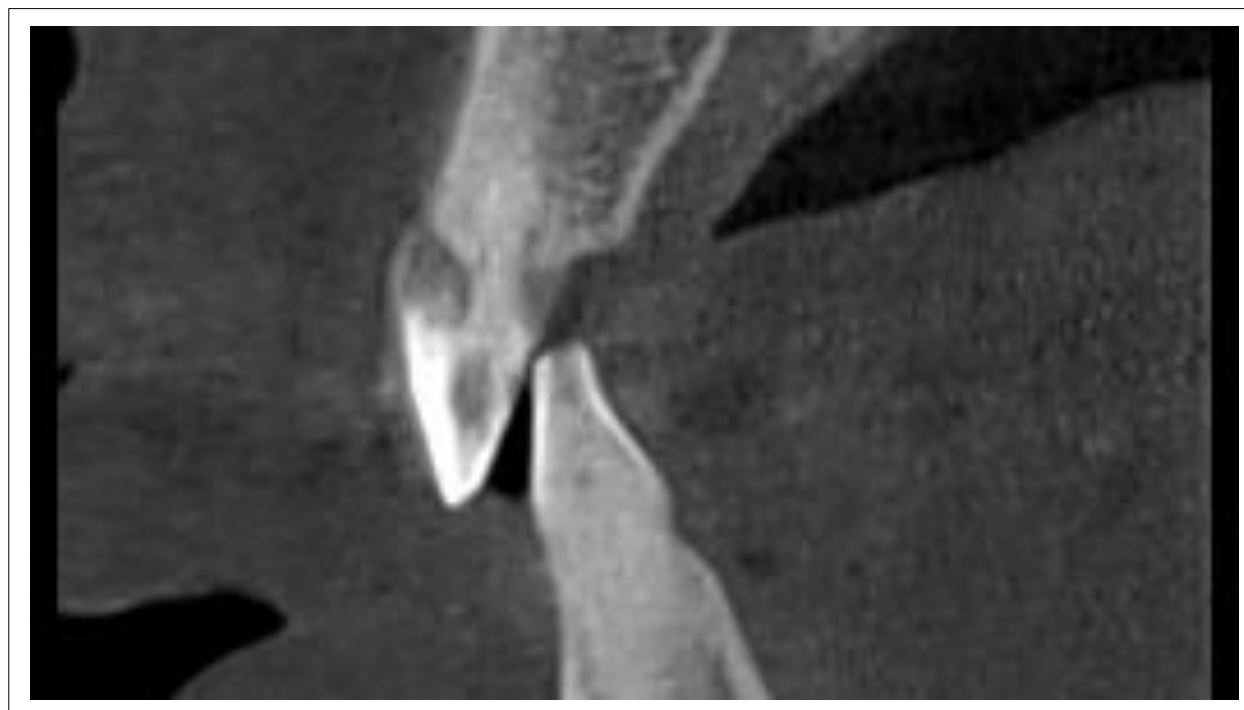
CBCT image of the affected maxillary left central incisor [FDI tooth number: 21], showing a cervical/root resorptive defect. The image demonstrates the three-dimensional extent of the lesion, its cervical localization, and its relationship with adjacent hard tissues and the root canal space.
